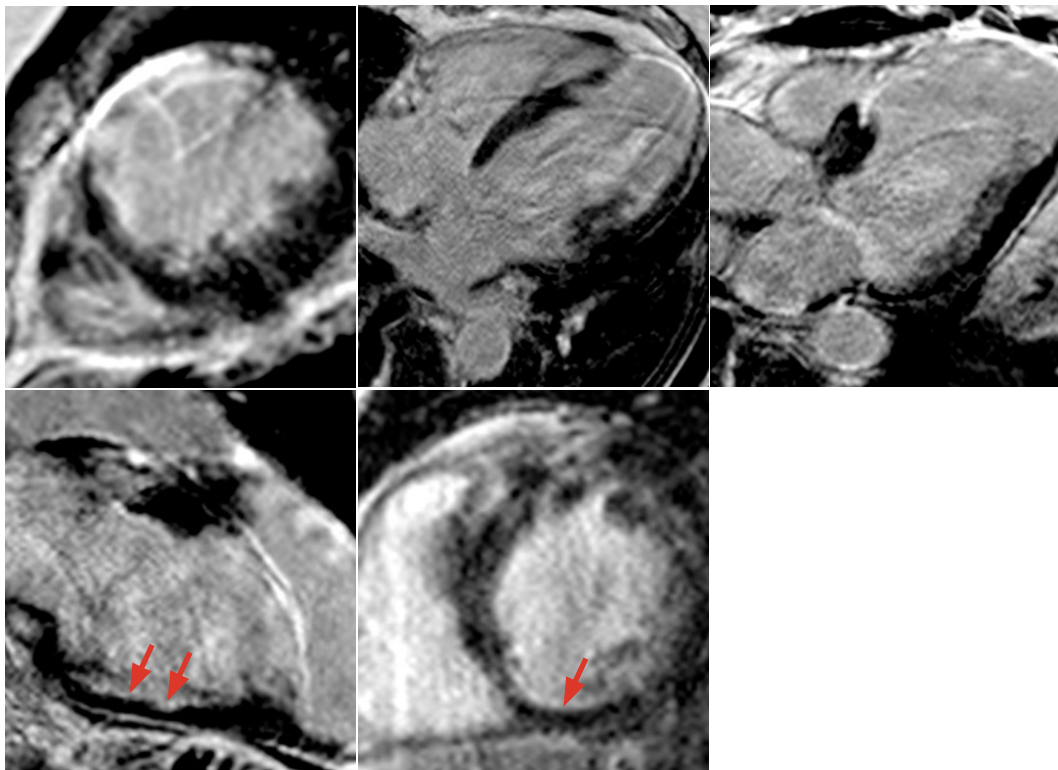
Late gadolinium enhancement on cardiac magnetic resonance imaging highlighting the existence of extensive myocardial fibrosis
